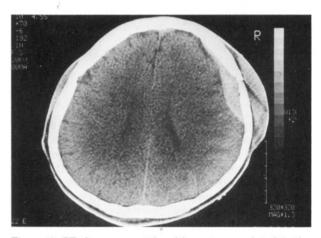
CT shows an epidural hematoma related to the fracture in a patient with marked skull asymmetry.
